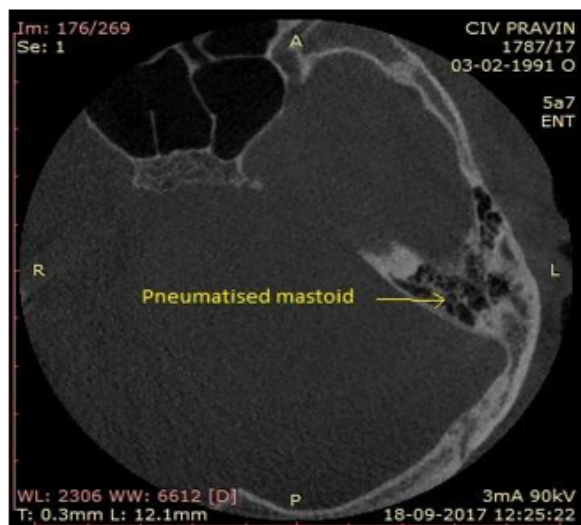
CBCT image showing pneumatized Mastoid
